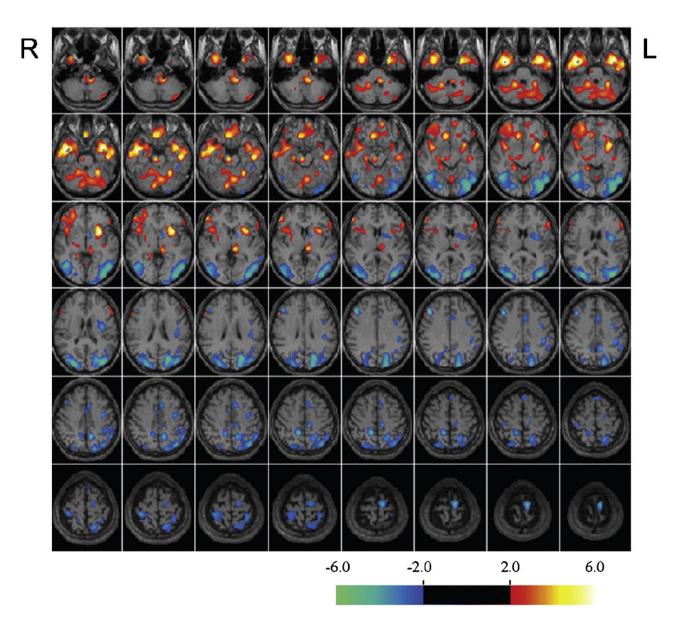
Single photon emission tomography images analyzed with the easy z-score imaging system (eZIS) [8]. Extensive reduction of rCBF is seen in the parietal and occipital lobes bilaterally, being more prominent on the left side. In contrast, there is increased perfusion of the orbitofrontal cortices and the anterior temporal lobes. The z-score maps are overlaid on the surface projection of a spatially normalized MRI template. Colors represent the statistical significance (z-score) of the decrease or increase in rCBF.
